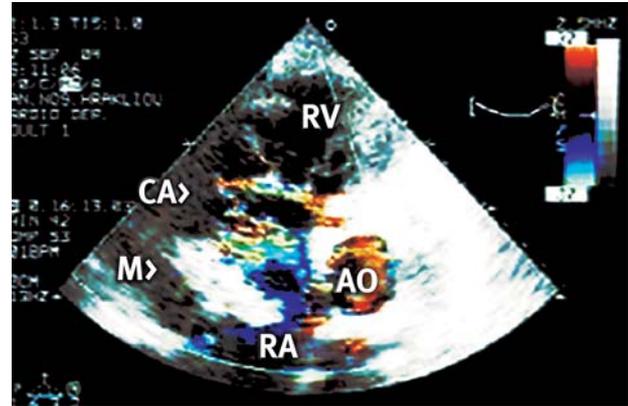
A modified left parasternal short axis view from Case 2, clearly showing an enlarged, probably right coronary artery (arising from the aorta at 11 o'clock), which supplies the right atrial mass. AO – aortic root; RV – right ventricle; CA – coronary artery; M – mass; RA – right atrium.
